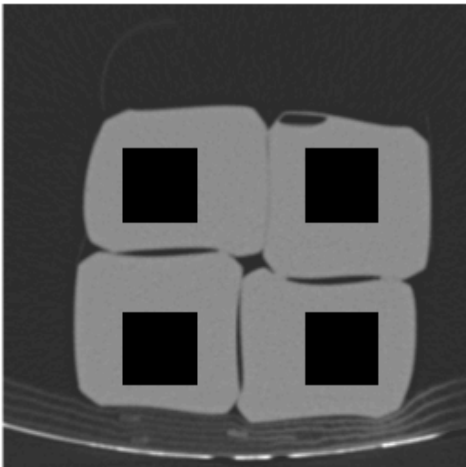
CT slice selected through the four bottles with an  $81 \times 81$  region of interest marked as a black square in each bottle. These regions of interest were used to assess the mean attenuation coefficient as a function of temperature.
